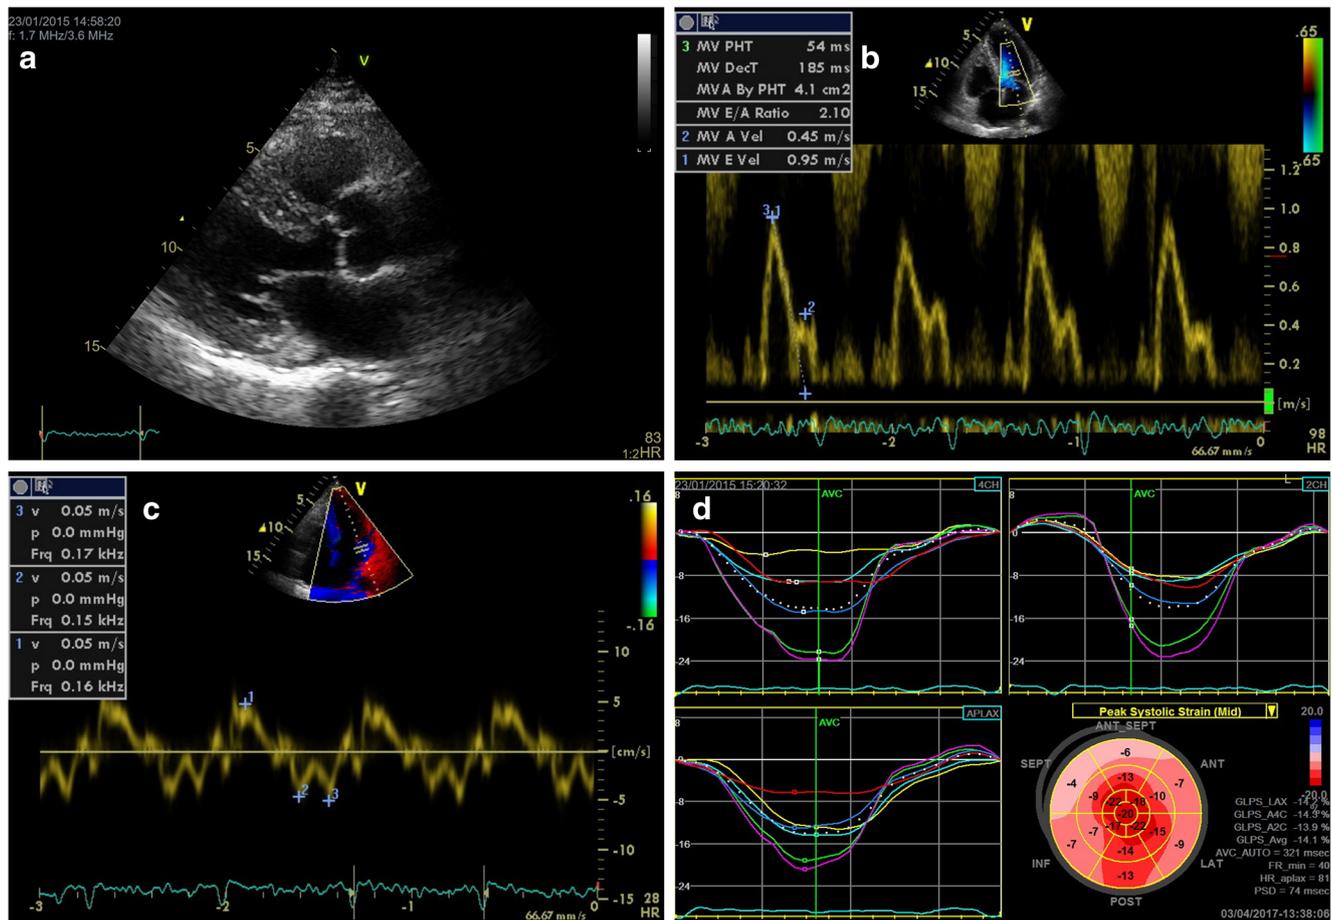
Parasternal long-axis view with increased LV wall thickness in a patient with cardiac amyloidosis a with advanced diastolic dysfunction as indicated by a ratio $E/A > 2$ b and reduced myocardial velocities by tissue
